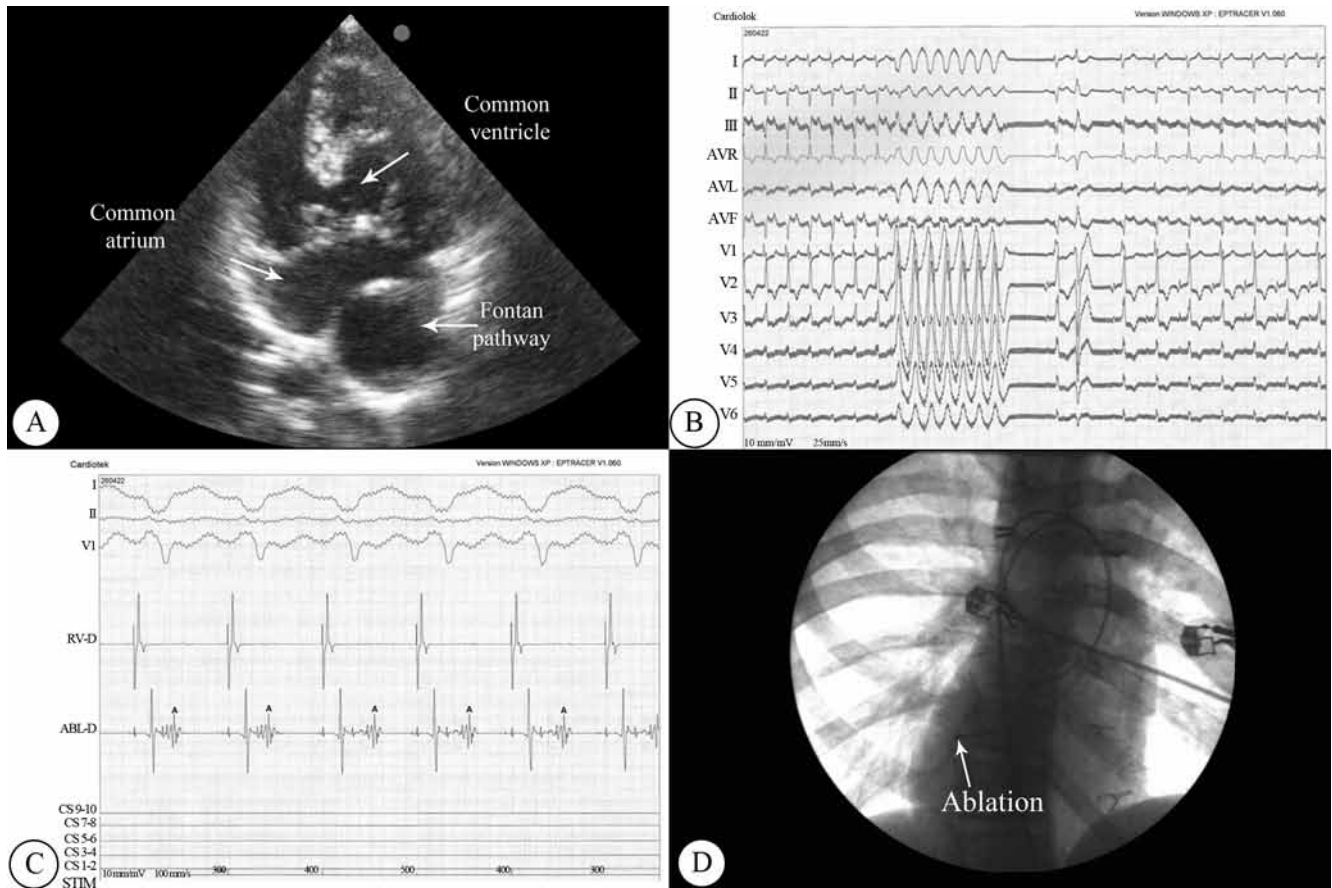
A) Two-dimensional echocardiographic image, depicting the straddling common atrioventricular valve. B) Orthodromic reciprocating tachycardia, terminated by ventricular pacing and resumption of sinus rhythm with a concealed bypass tract. C) Position of the atrial and the ablation catheters, both through the retrograde aortic approach in right anterior oblique projection. D) Successful ablation during ventricular pacing and retrograde conduction purely over the atrioventricular node
